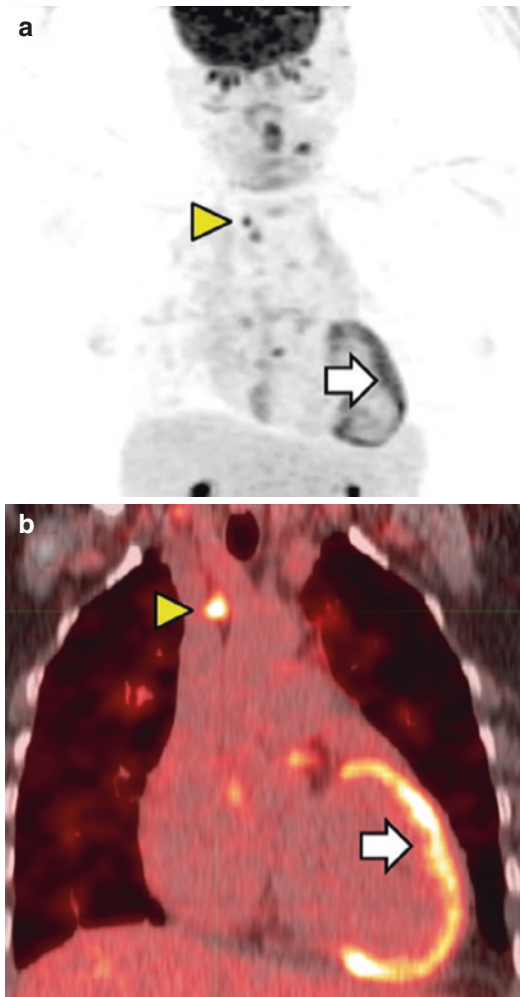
Maximum intensity projection (MIP) image (a) and coronal PET/CT (b) images from a myocardial [^{18}F]FDG-PET/CT study performed in a patient with suspected sarcoidosis. Increased activity is seen in the left ventricular myocardium (*white arrow*) despite suppression of glucose metabolism, indicating active inflammation due to sarcoidosis. Additionally, mediastinal lymph nodes with increased [^{18}F]FDG uptake are present, and one of these nodes involved by sarcoidosis is indicated by a *yellow arrow head*
